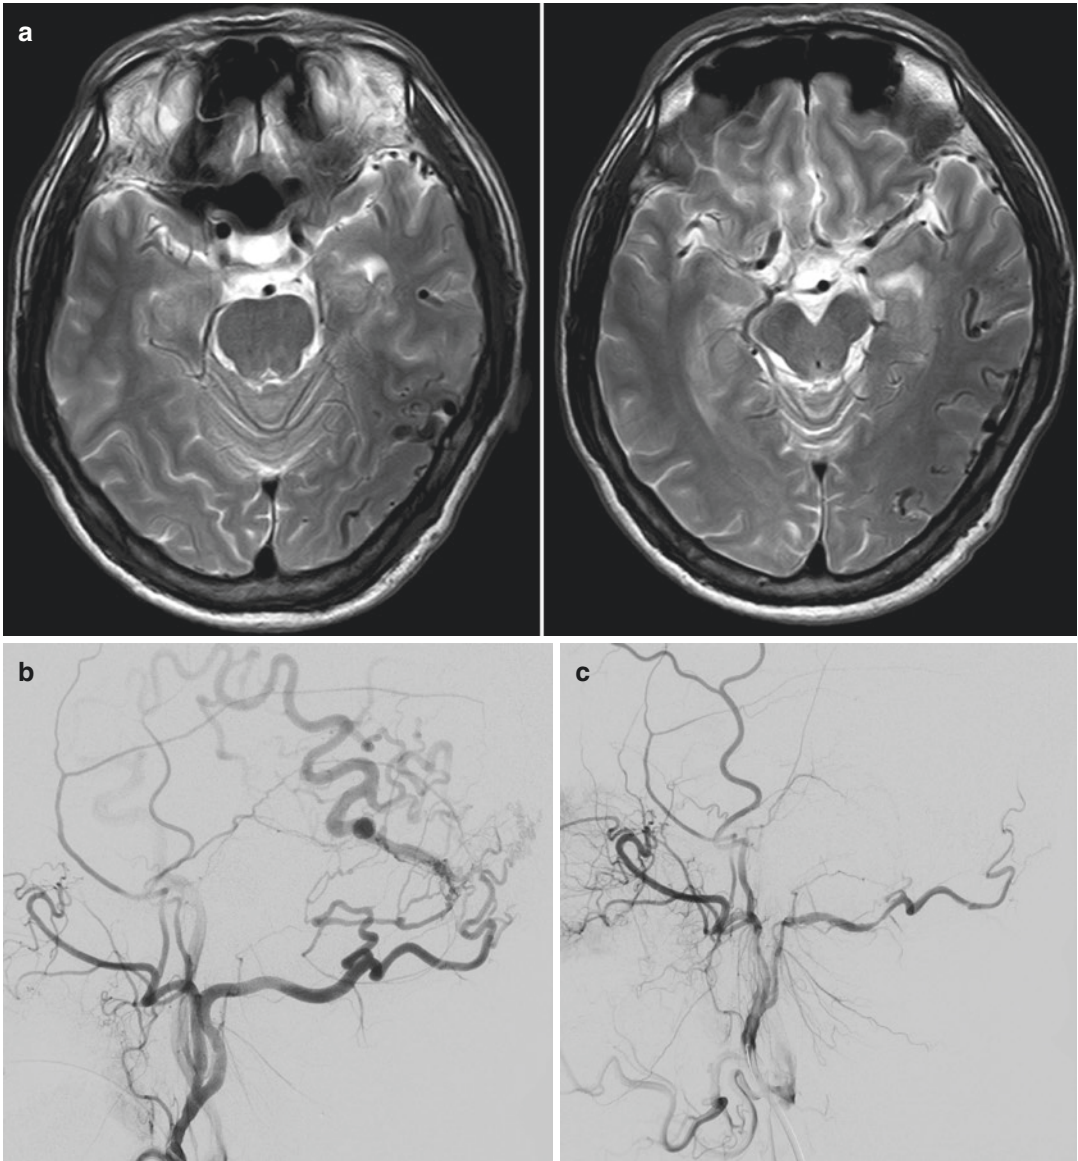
A 43-year-old woman presented with a seizure. (a) T2-weighted magnetic resonance images show the flow voids from large arterialized draining veins. (b) Digital subtraction angiography (DSA) shows the dural arteriovenous fistula (DAVF) at the left transverse sinus. Main feeding arteries are the stylomastoid branch and transmastoid branch of occipital artery and the middle
